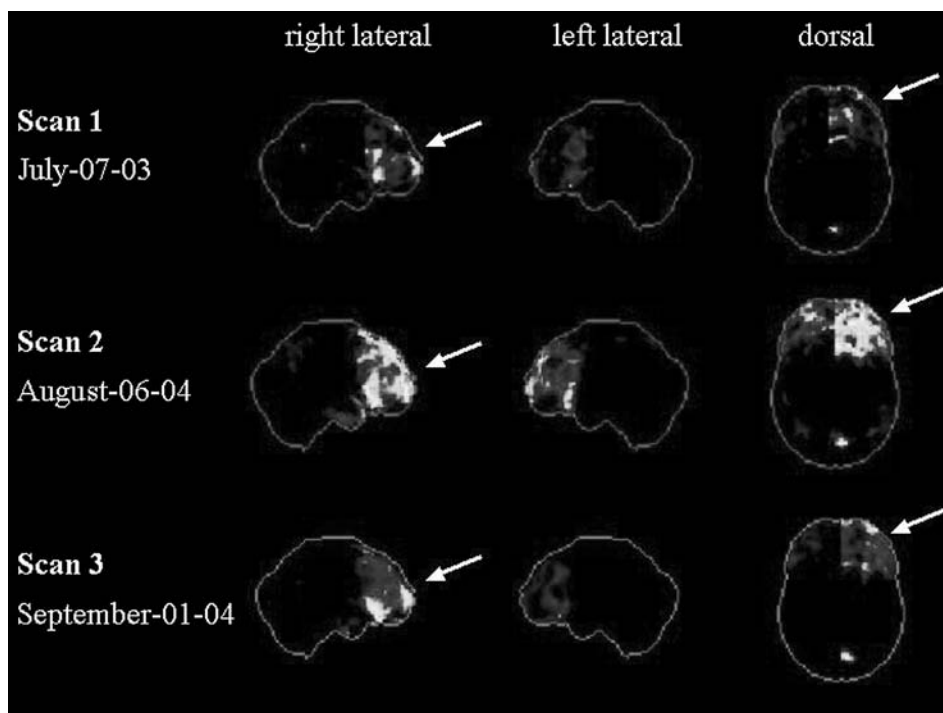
^{18}F -FDG-PET findings: the comparison with the normal database showed marked decrease of cerebral frontal glucose metabolism pronounced on the right side (see arrows) over the 13-month period (scans 1 and 2). Under aripiprazole treatment, partial restitution of disturbed frontal glucose metabolism could be observed (scans 2 and 3).
